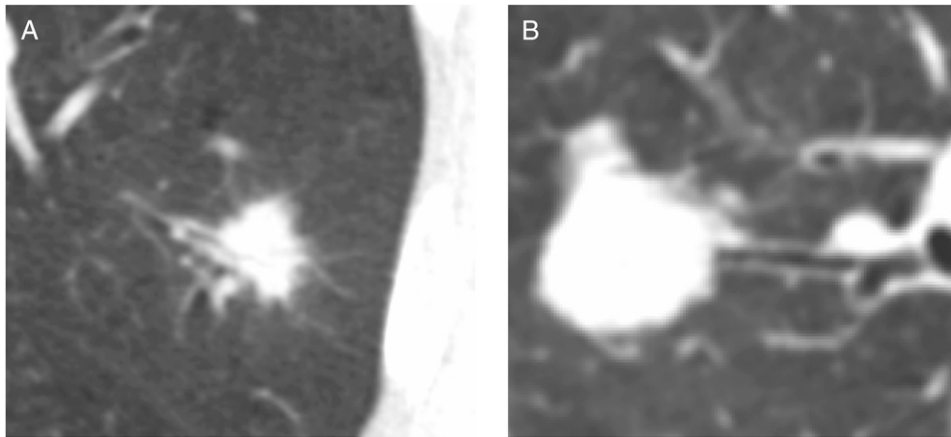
A, Bronchus sign in a patient with a pulmonary adenocarcinoma diagnosed by electromagnetic navigation bronchoscopy (ENB). B, Magnified CT image of a pulmonary nodule with a visible bronchus sign. ENB was also diagnostic in this case.
